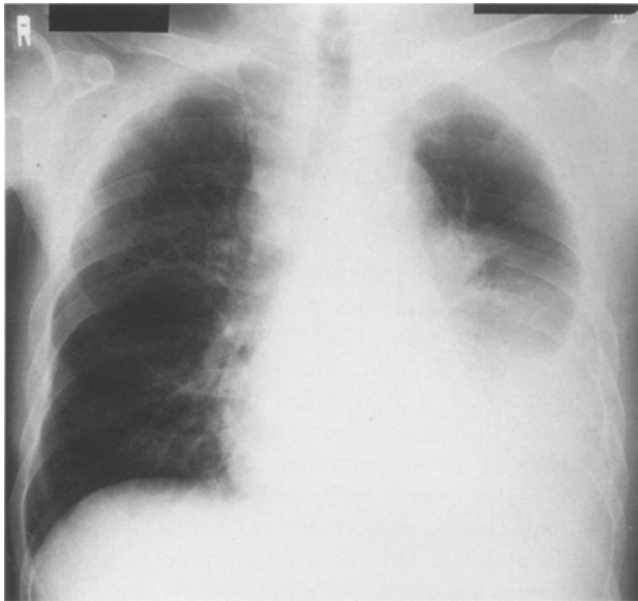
Chest X-ray before treatment, revealing large left pleural effusion and right hilar adenopathy
